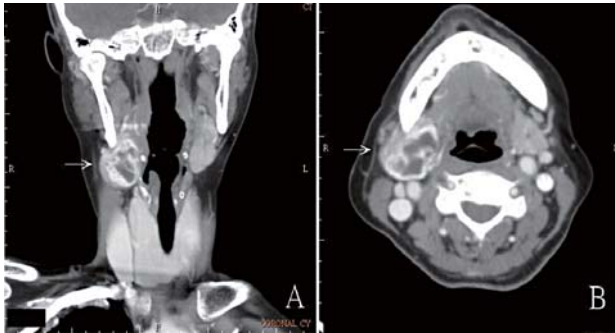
Coronal (A) and axial (B) computed tomography scans demonstrate a mass located in the right submandibular region (White arrow).
